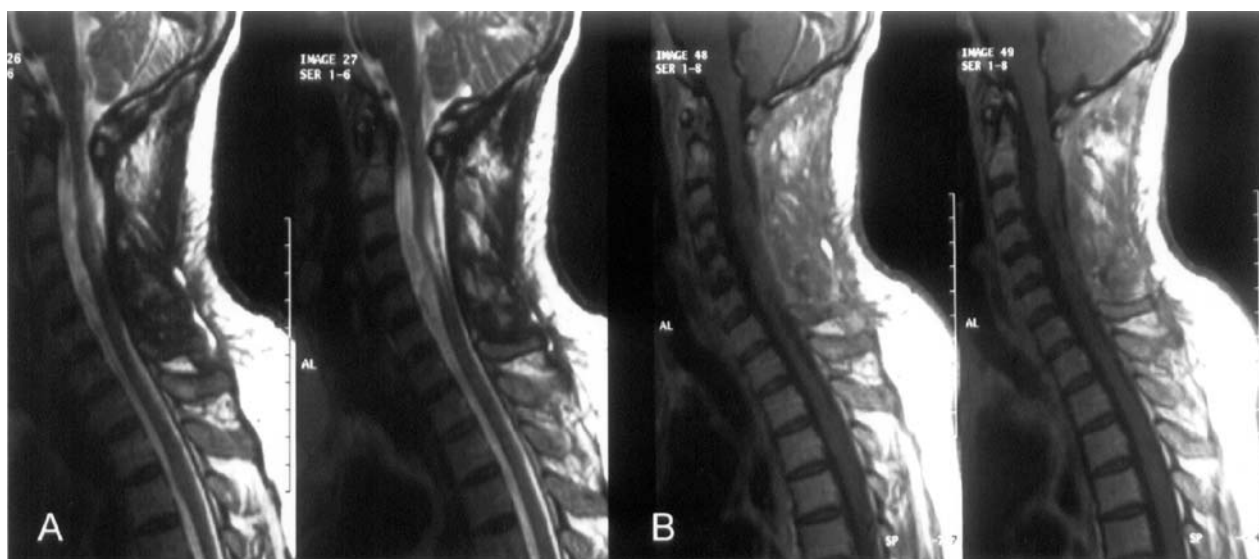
MRI three months after complete tumour resection with complete restitution of cord swelling, but with postoperative spinal cord defect at level C3–C5 (T2-weighted images – A). T1-weighted images (B) revealed no pathological contrast enhancement in the cervical spinal cord but cord adhesions at level C5 and C6
